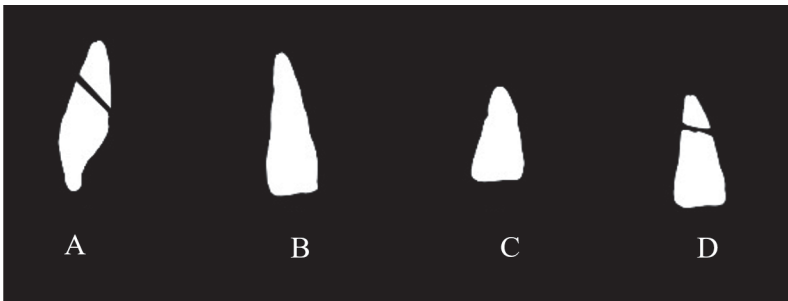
The different radiographic appearances of an oblique root fracture using different projections.
